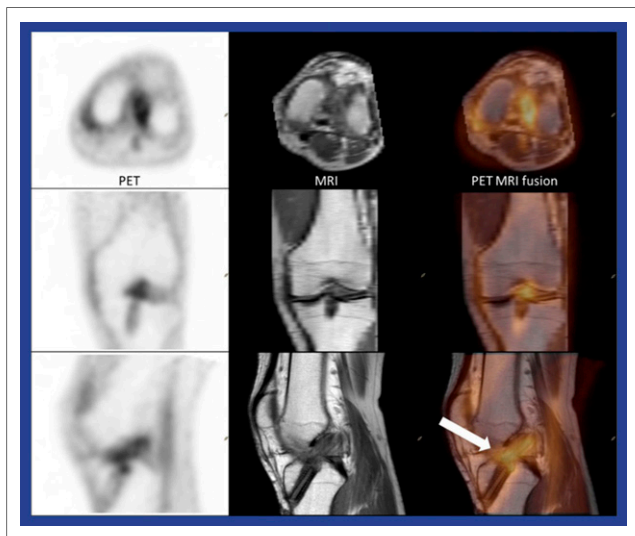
Dynamic ^{18}F -FDG PET in anterior cruciate ligament (ACL) graft viability. Static PET image (left) reconstructed from listmode data acquired 70–75 minutes after injection of 111 MBq (3 mCi) ^{18}F -FDG. Proton density and T1-weighted MR imaging sequences (middle) were acquired in all 3 planes with a 3D high-resolution series. Fusion of PET and MR images (right) for evaluation of ACL graft and bone tunnel uptake showed location of ACL graft (arrow), with marked uptake through the graft as well as the femoral and tibial bone tunnels.
